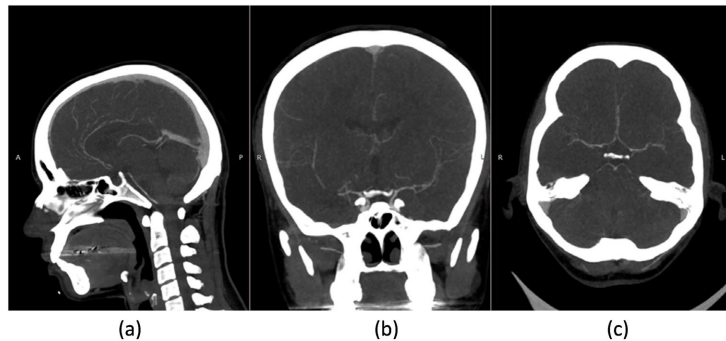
Cranial CT angiography in sagittal (a), coronal (b), and axial (c) views, arterial phase with intravenous contrast, showing global reduction of cerebral circulation.
